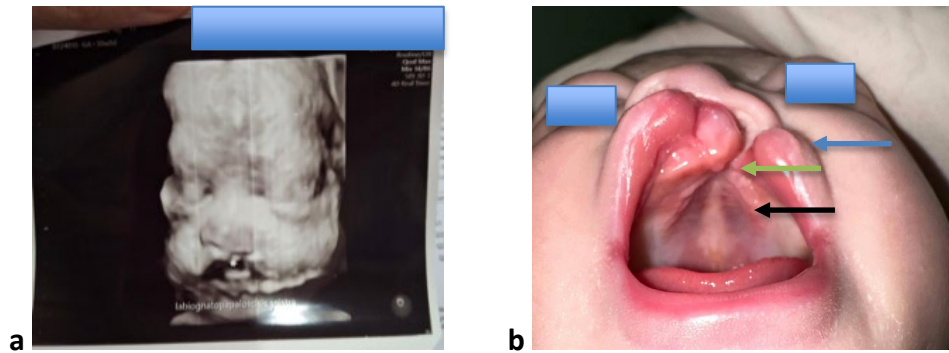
(a) Prenatal 3D ultrasound at 30 weeks of gestation shows unilateral cleft (b) Neonatal clinical shows unilateral cleft involving the upper lip (blue arrow), alveolar ridge (green arrow), and palate (black arrow)
